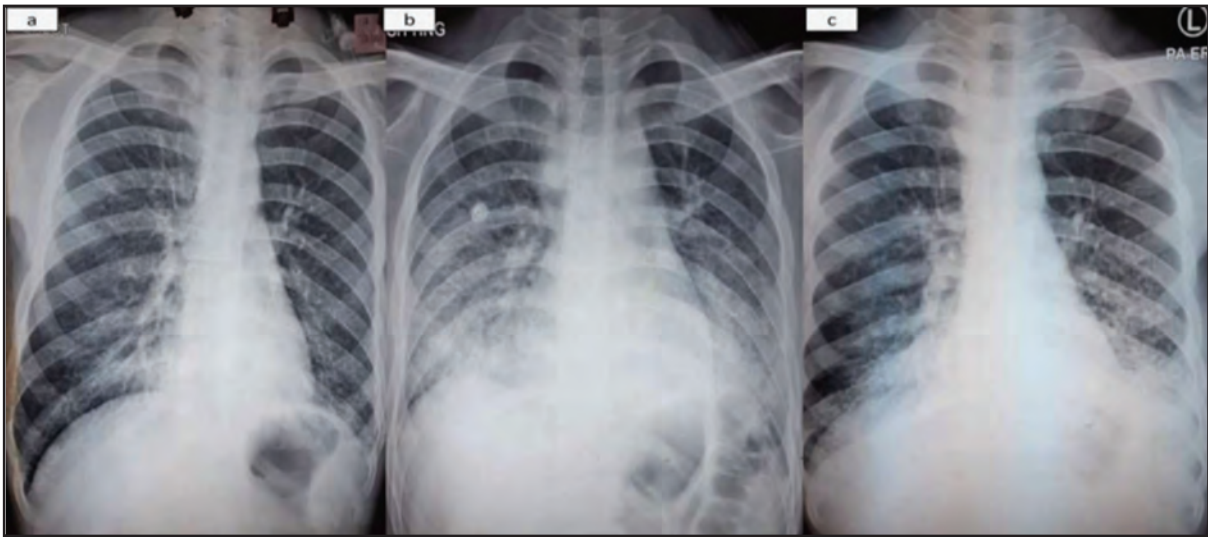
Serial chest radiographs. a) During the first admission, bilateral lower zone nodular consolidation changes. b) During the second admission, consolidation worsens. c) After 2 weeks of treatment during the second admission, consolidation has improved.
